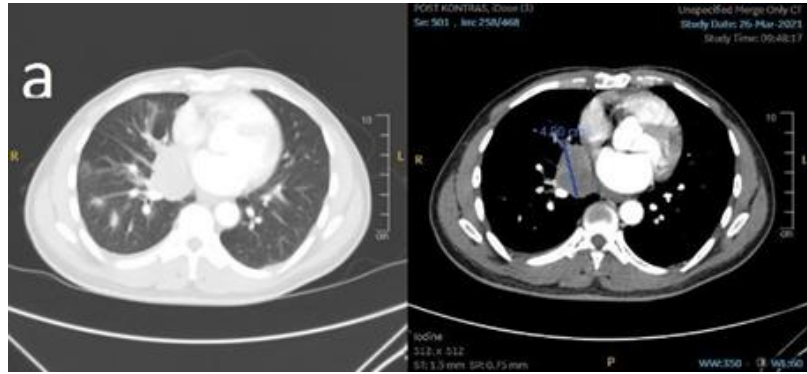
Thoracic CT scan before administration of Afatinib on March 26th, 2021.
